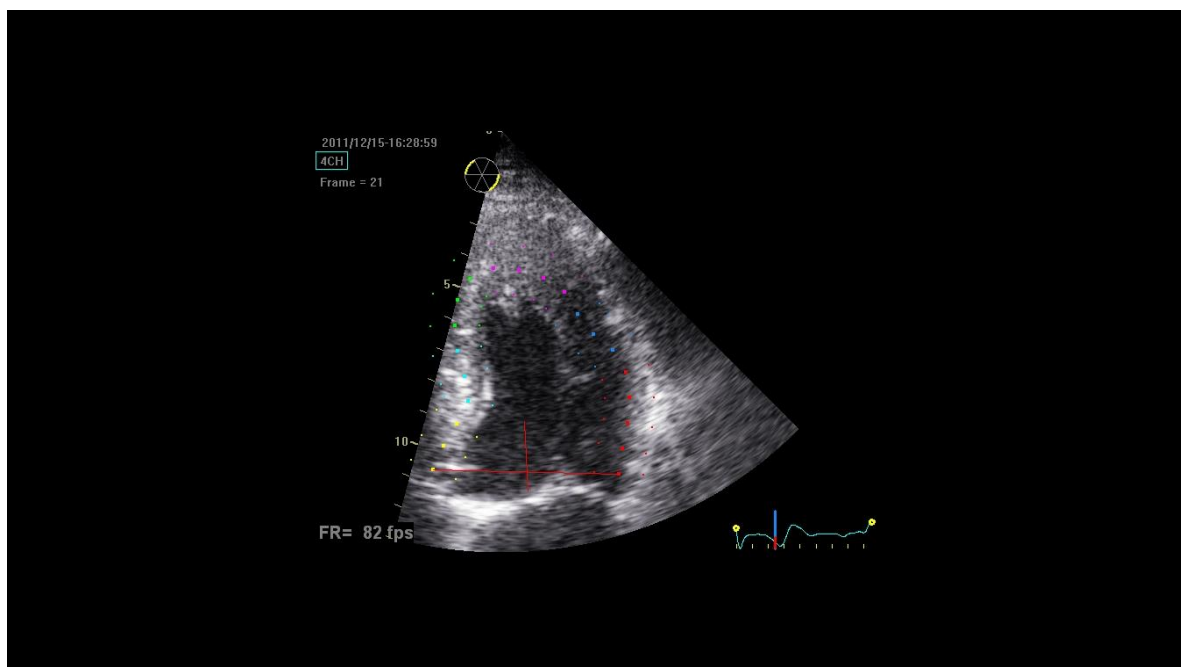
Echocardiographic speckle tracking of the myocardium in the apical 4 chamber view
